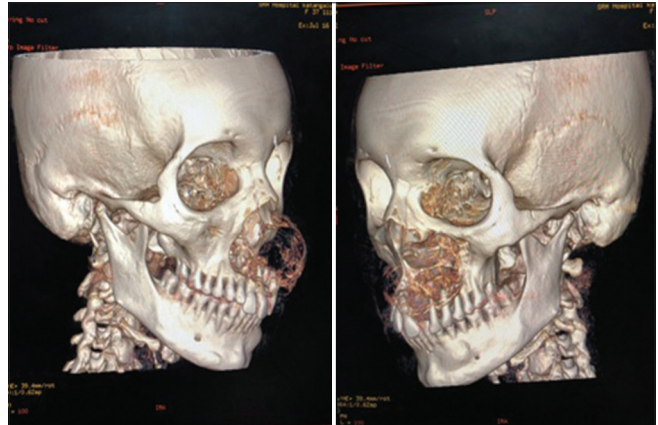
Three dimensional reconstructed computed tomography scan shows the osteolytic lesion involving the anterior maxilla
